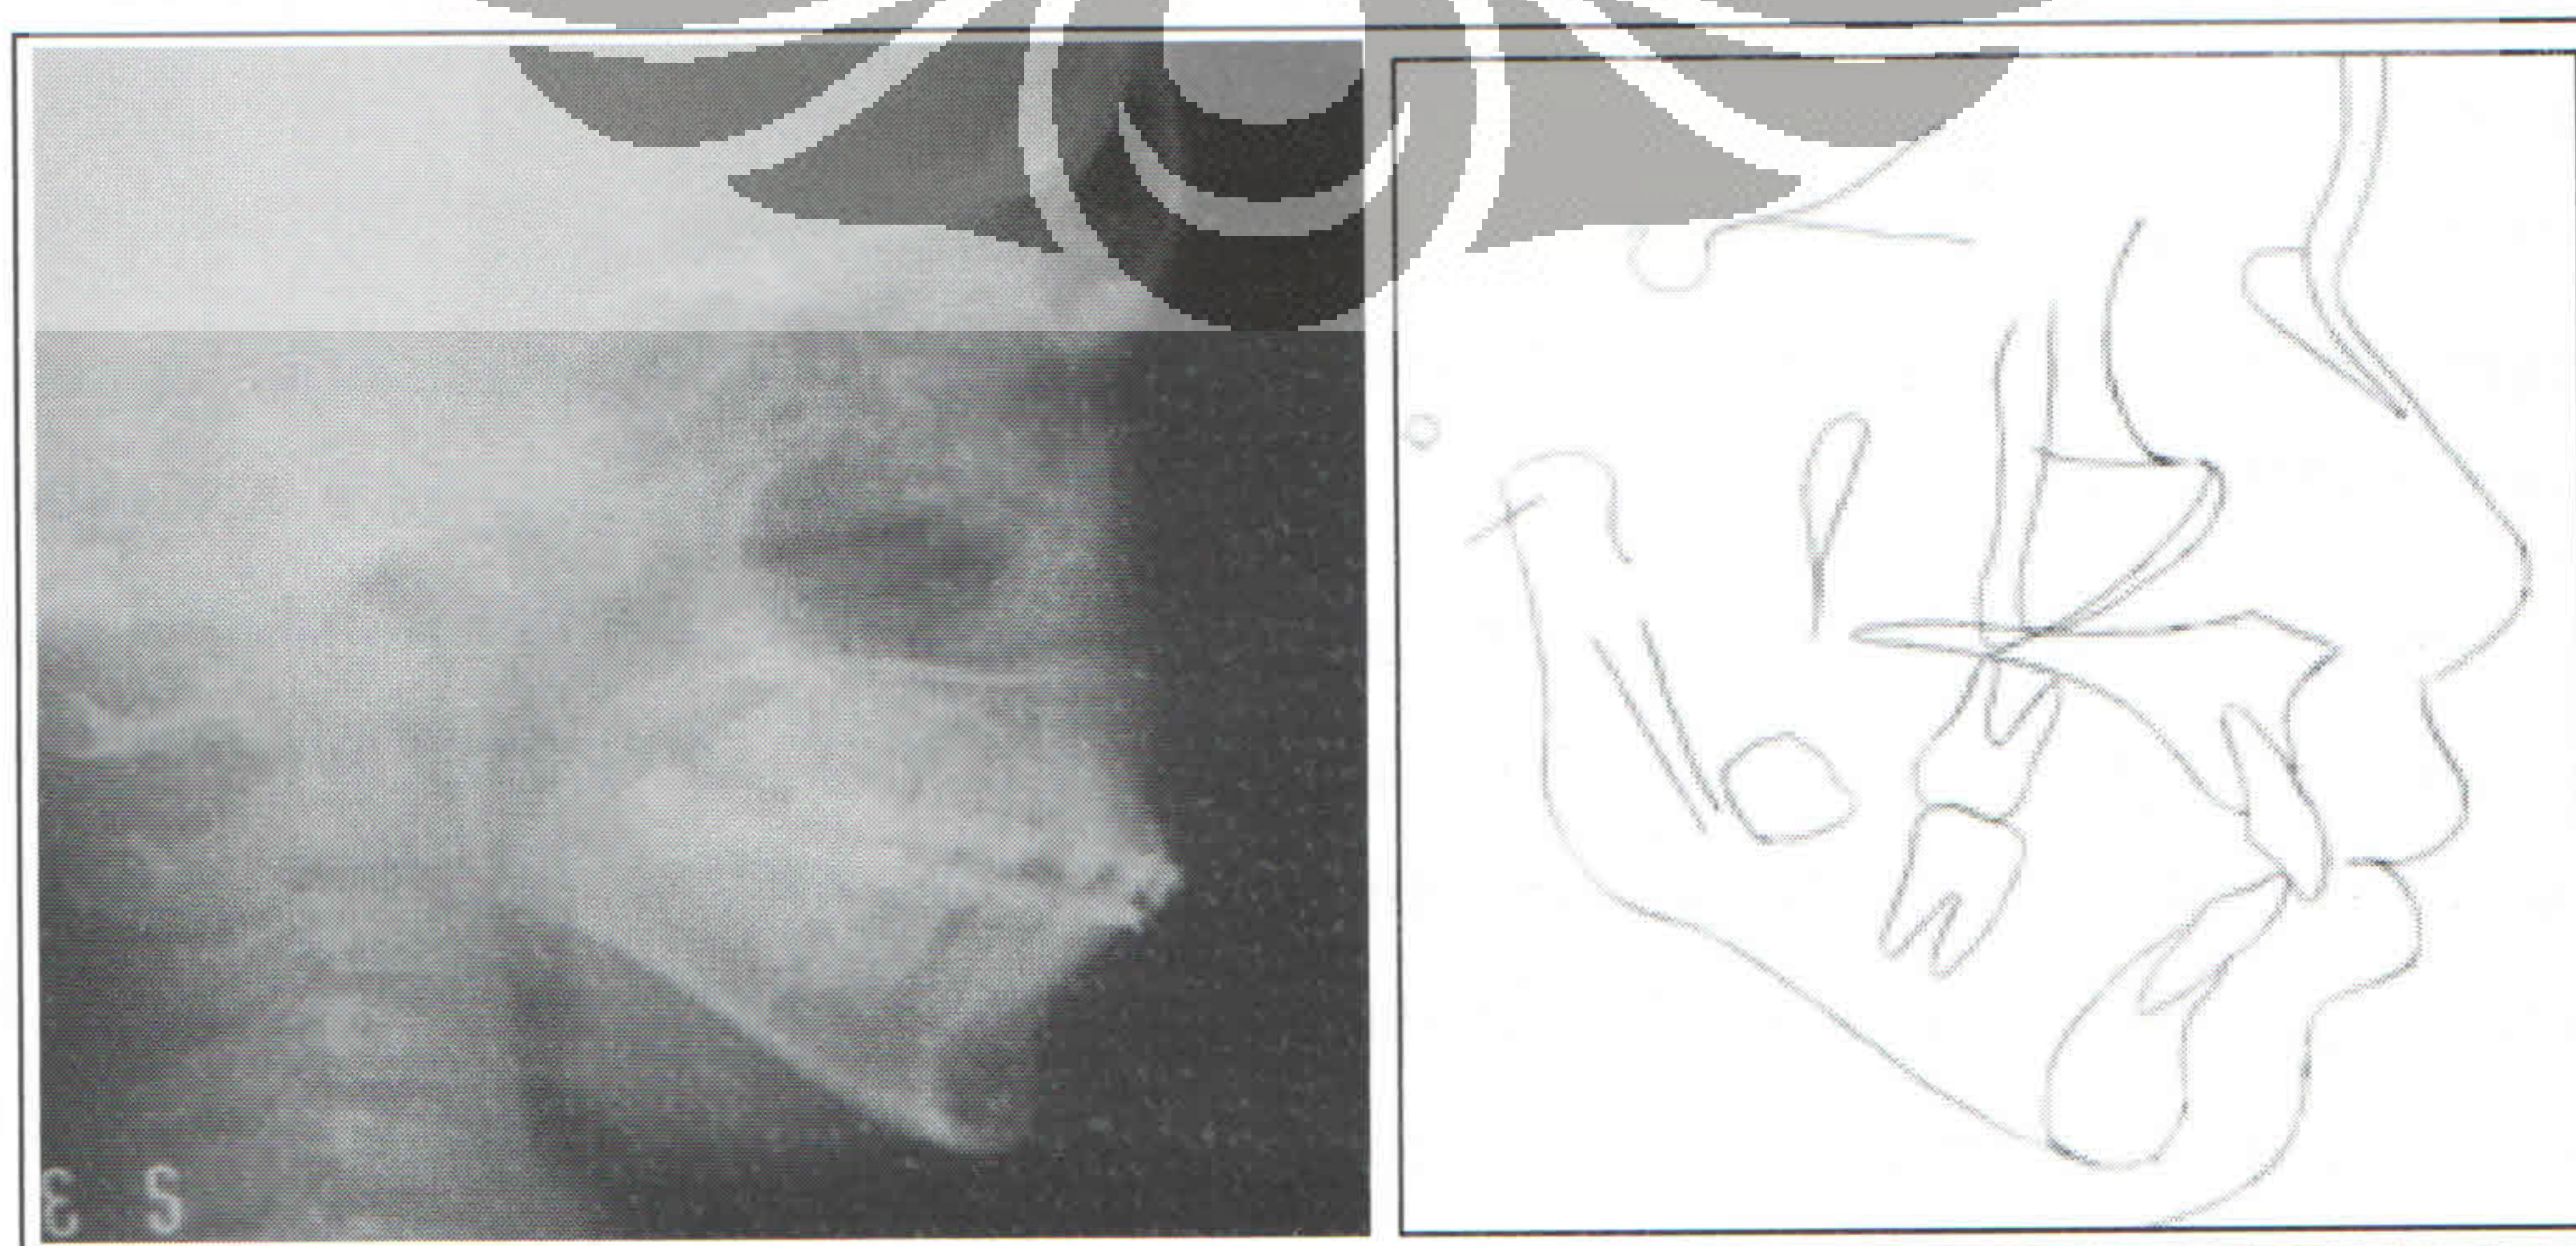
Cephalometric radiographs taken 7 months into treatment (020908).
